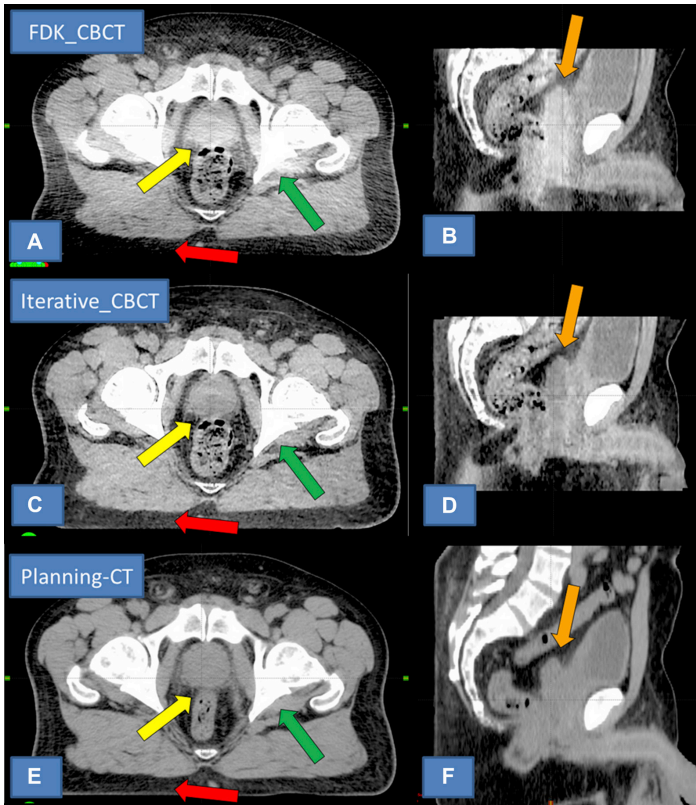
Comparison of reconstructed images of a prostate patient, either acquired with a CBCT (top and centre row) or with a fan-beam CT (bottom row). In the case of CBCT, the images were reconstructed using the conventional FDK algorithm (top row, see Section 1.2.5) as well as an iterative algorithm (centre row). Left column: axial plane; right column: sagittal plane. Arrows point to features for comparison between imaging modalities. This figure is taken from the work by Gardner et al [14]; their article is licensed under the [CC BY-NC-ND 4.0 license](https://creativecommons.org/licenses/by-nc-nd/4.0/). ©2019 Gardner et al.
